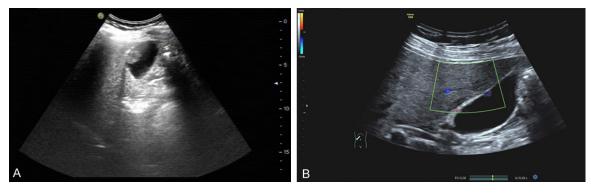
Blood flow features of the ultrasonically diagnosed adenoma. Hyperechoic mass in the anterior wall of the gallbladder body with irregular morphology and well-defined outline (A). High-frequency ultrasound showed hyperechoic, mass-like attachment at the anterior wall of the gallbladder, and a distinct basal wide blood flow signal at the base of the lesion (B).
